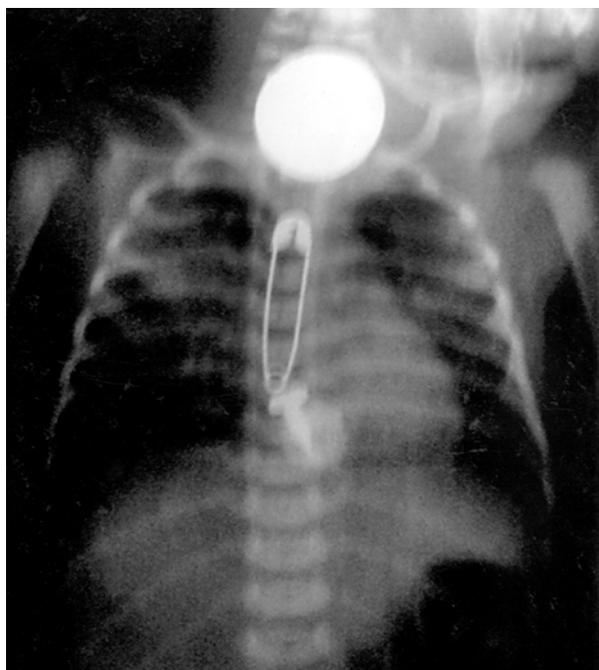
X-ray chest PA view showing multiple foreign bodies (rounded shadow, safety pin, screw, cotton piece).
